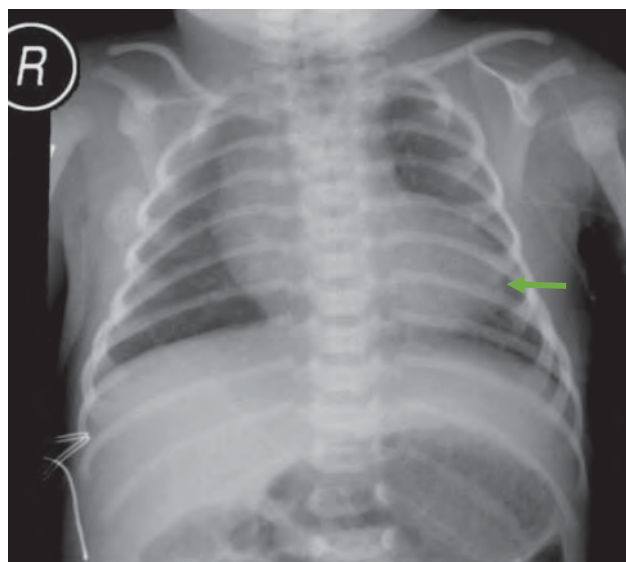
Frontal radiograph of the chest in a patient with tetralogy of Fallot shows decreased pulmonary vascularity and an upturned apex of the heart (arrow). This is often referred to as a “boot”-shaped heart.
